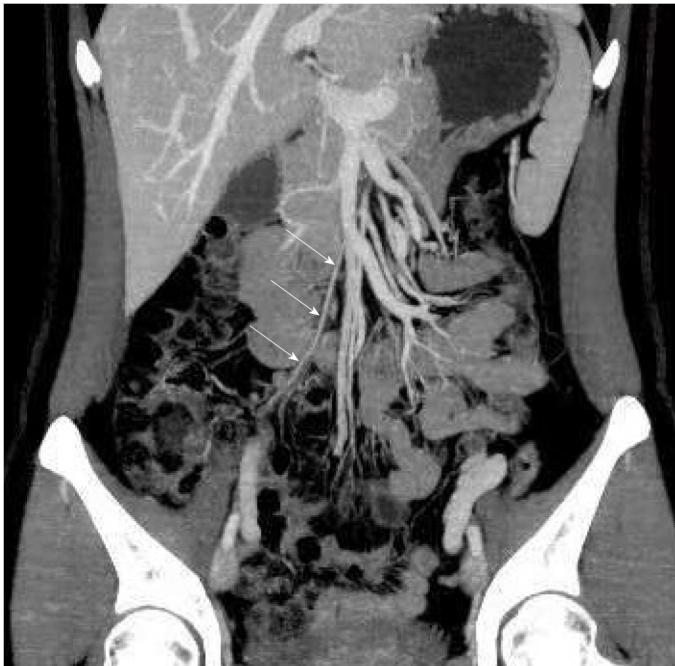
Follow-up computed tomography scan after 1 mo. Coronal reformatted image with maximum intensity projection showed the ileocolic artery (arrow). The site of previous thrombophlebitis in the ileocolic vein had disappeared, which indicated that the vein was completely occluded and that collateral circulation was established.
